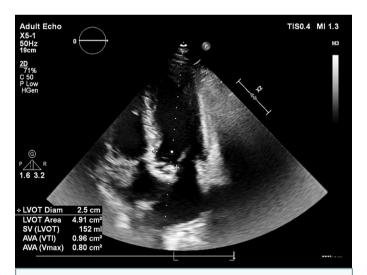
Transthoracic echocardiographic image demonstrating severe calcified aortic stenosis. The LVOT diameter was measured at 2.5 cm, resulting in a calculated area of 4.91 cm² and a stroke volume of 152 mL. Although this value appears relatively high for severe AS, it may reflect preserved systolic function and should be interpreted in clinical context. The aortic valve area was calculated as 0.96 cm² (VTI method) and 0.80 cm² (Vmax method), confirming severe stenosis
